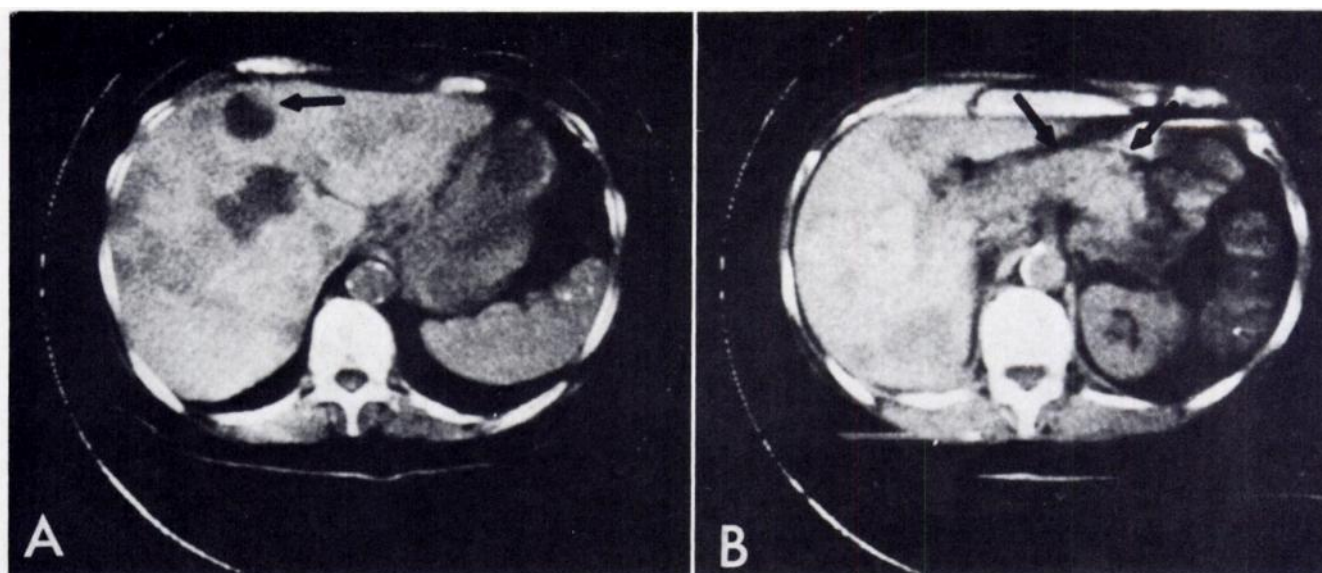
CT scans showing metastasis from carcinoma of pancreas with metastatic lesions throughout liver. A, Two lesions with very low density, probably a result of cystic degeneration, one seems to have mural nodule (arrow). B, Primary tumor in body and tail of pancreas (arrows).
